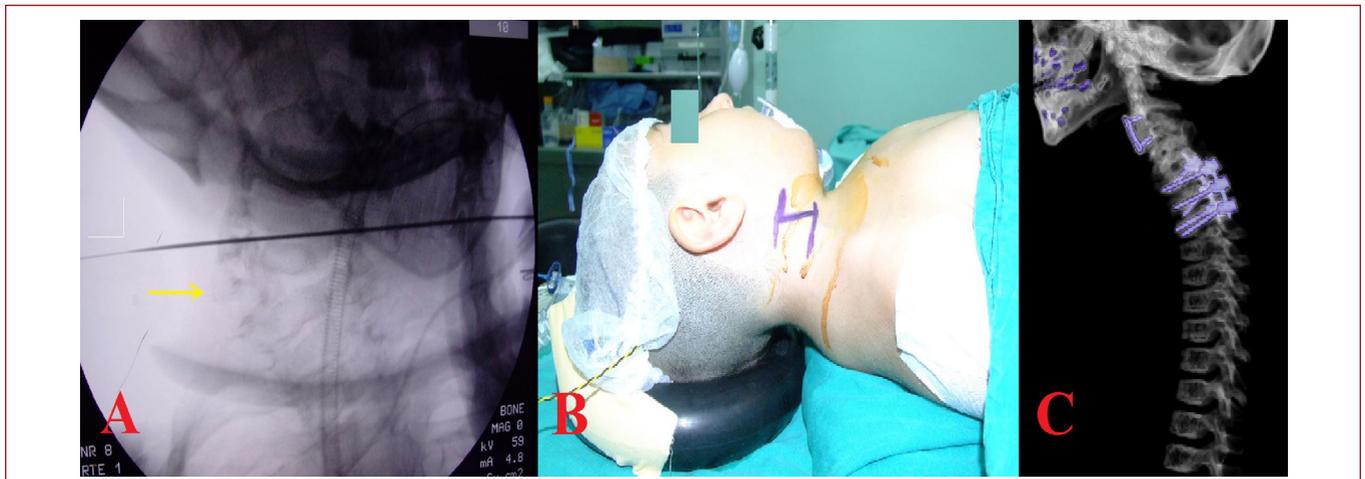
a) and b) The detection of the incision site during the operation, c) 3-CT image after the operation
